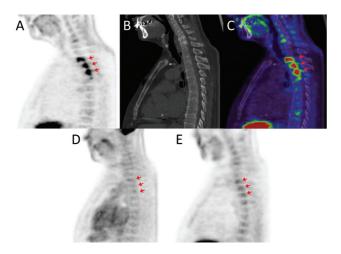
Sagittal views of ¹⁸F-choline positron emission tomography (PET) (A), computed tomography (CT) (B) and PET/CT fusion images (C) showing an example of nonspecific intense bone uptake (*arrows*, thoracic vertebrae 2–4, maximum standardized uptake value: 18.1). Additional ¹⁸F-fluorodesoxyglucose (¹⁸F-FDG) PET (D) did not show signs of malignancy and follow-up ¹⁸F-choline PET (E) 3 months later showed a near normalization of uptake. The cause of the increased ¹⁸F-choline uptake was not elucidated.
